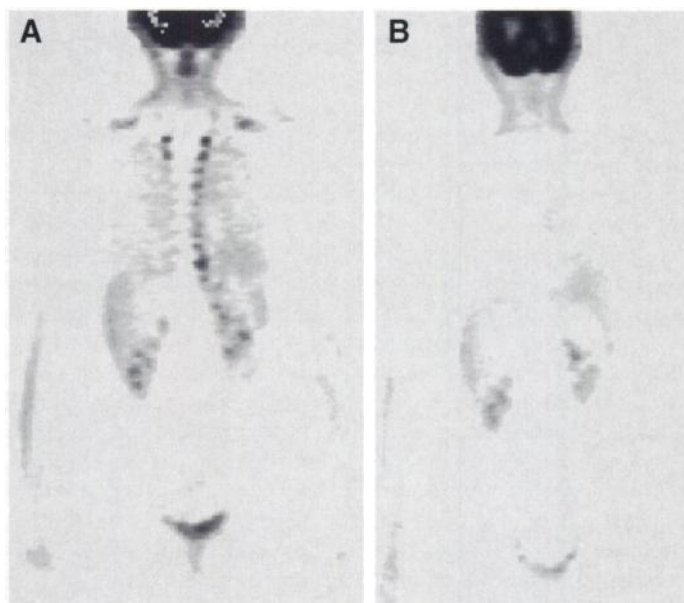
(A) Paravertebral uptake of FDG is associated with the pattern of increased neck uptake in the same patient as in Figure 1. (B) Paravertebral uptake is also abolished after administration of diazepam.
